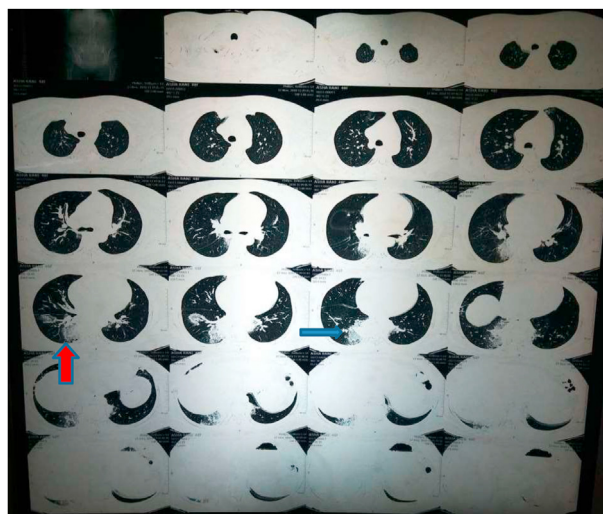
HRCT chest showing intralobular reticulation with right lower lobe predominance.
